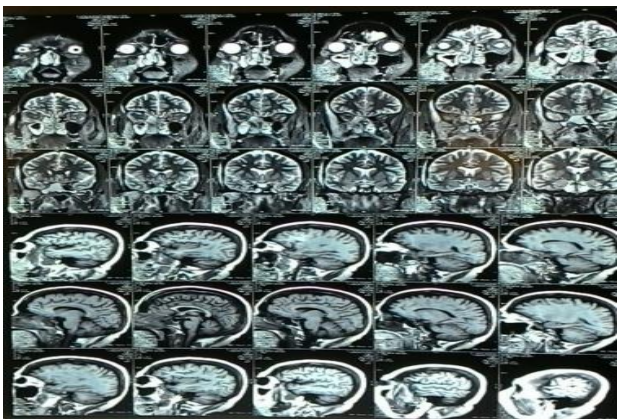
MRI Brain showing pan sinusitis and tiny hemorrhagic contusion.
